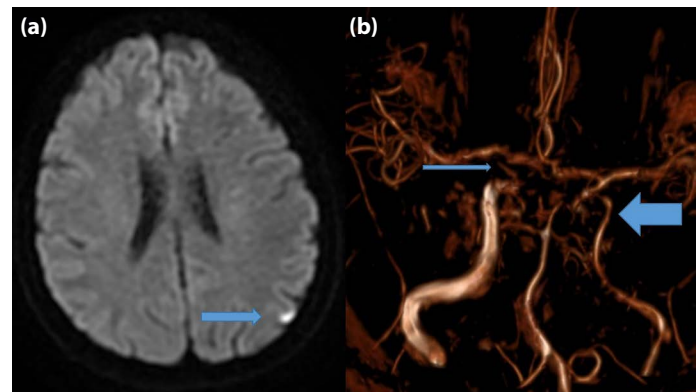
(a) DWI MRI showing left cortical hyperintensity. (b) TOF MR-Angiography: Arrows pointing to a cavernous ICA. (c) Cervical MR-Angiography: Arrow indicating the left ICA at the bifurcation. (d) Digital Subtraction Angiography: Arrow highlighting the Moyamoya appearance at the level of the cavernous ICA.
